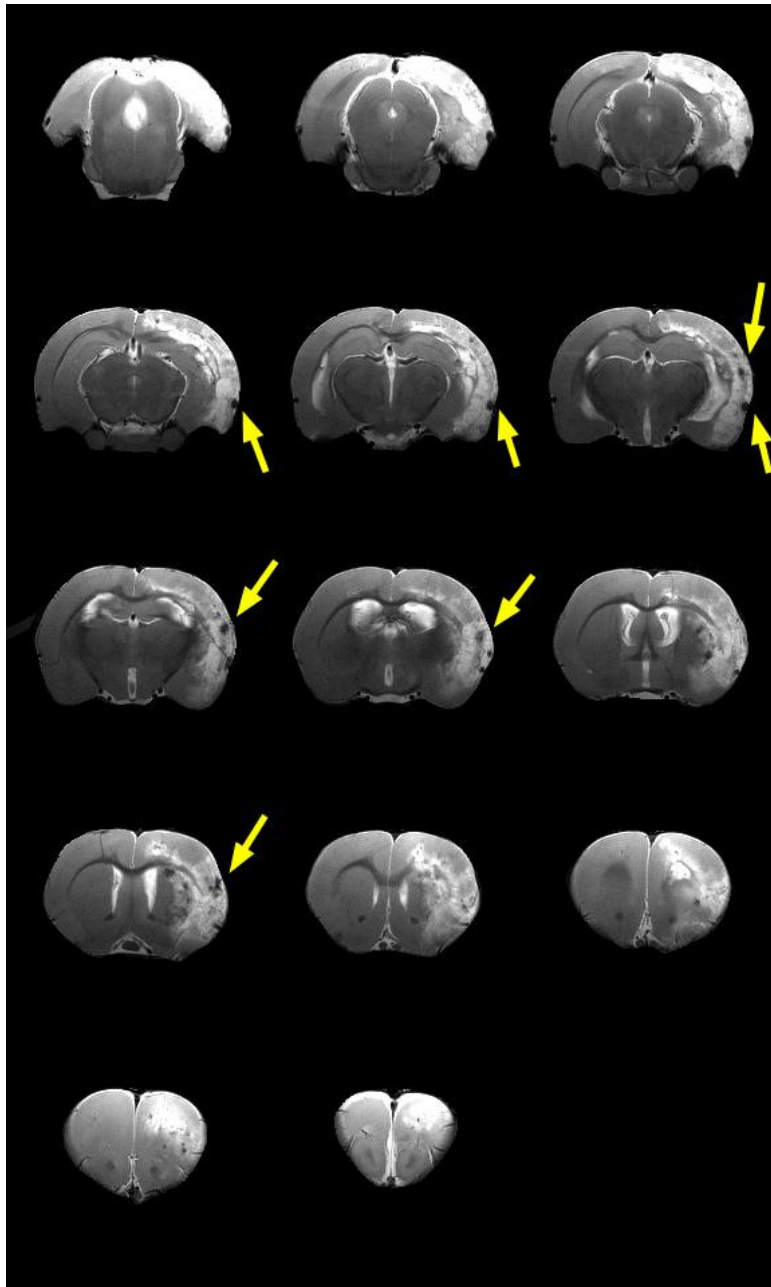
T₂ weighted MRI 7 days after the onset of cerebral ischemia and MSCs injection.
